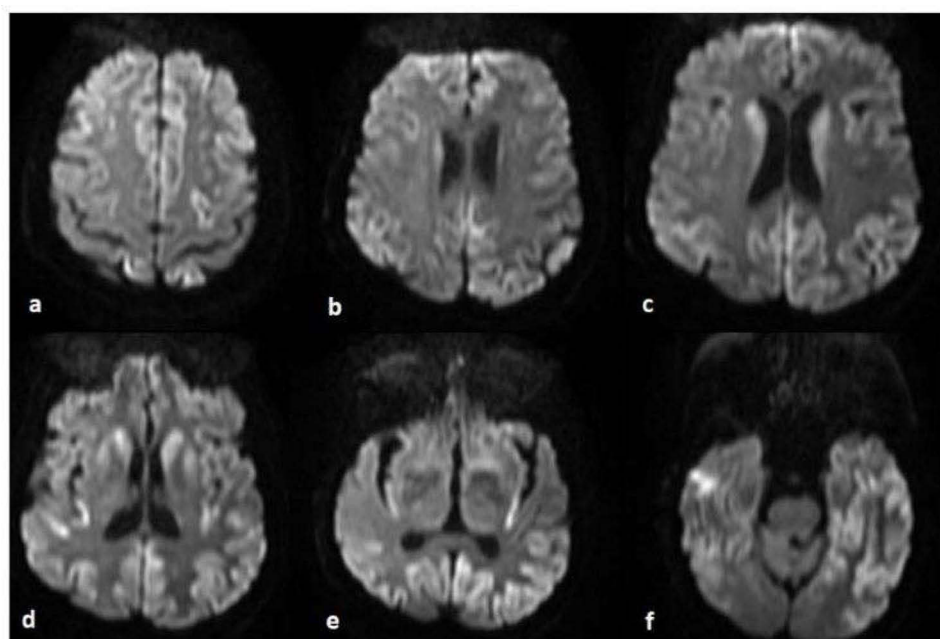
Serial axial diffusion-weighted magnetic resonance images (DWI) demonstrating cortical hyperintensity (cortical ribboning) and basal ganglia involvement. (a): Frontoparietal cortex. (b–e): Occipito-temporal cortex. (f): Temporal cortex. (c and d): Note the characteristic high signal intensity in the heads of the caudate nuclei and putamen.
